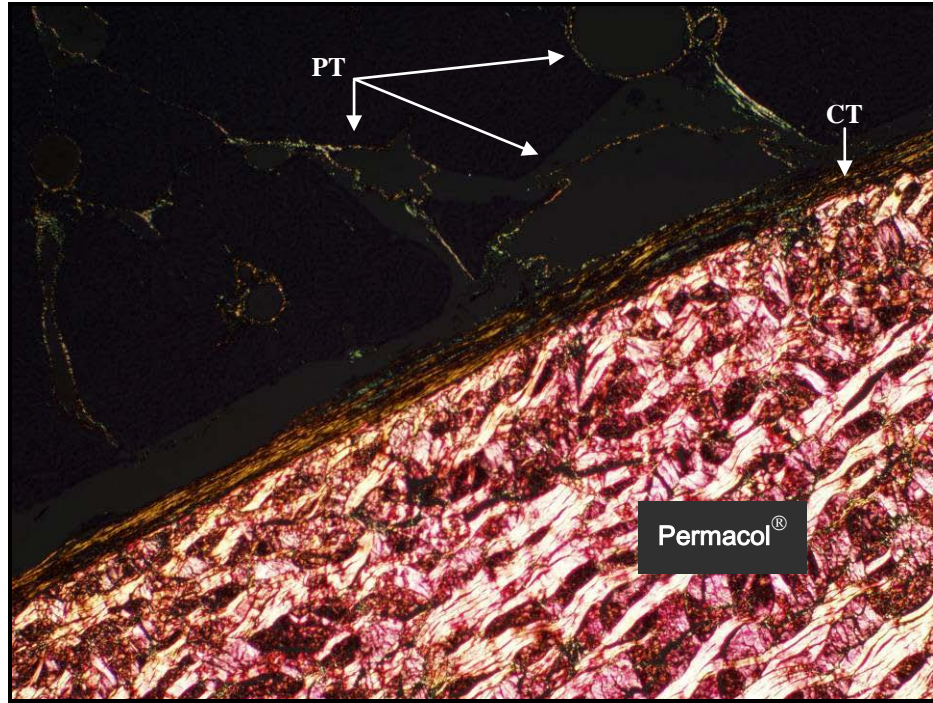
Liver portal tracts (PT), collagenous tissue (CT) and Permacol® implant after 3 months implantation in the liver (picro sirius red, 40X).
